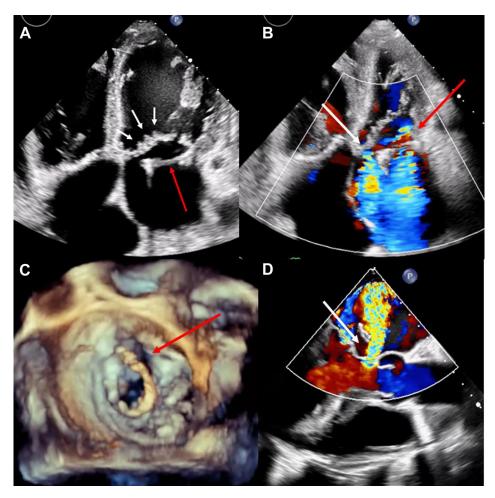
Transthoracic and transesophageal echocardiography showing mitral endocarditis and its complications. (A) Transthoracic echocardiographic 4-chamber view showing mitral valve leaflet vegetations (white arrows) and ring dehiscence (red arrow). (B) Transthoracic echocardiographic 4-chamber view with colour Doppler showing severe mitral valve regurgitation (red arrow) and a fistula at the mitral-aortic junction (white arrow). (C) Transesophageal echocardiography with a 3-dimensional view of mitral ring dehiscence (red arrow). (D) Transesophageal echocardiography in 120° view showing a fistula between left ventricle and left atrium at the mitral-aortic junction (white arrow).
